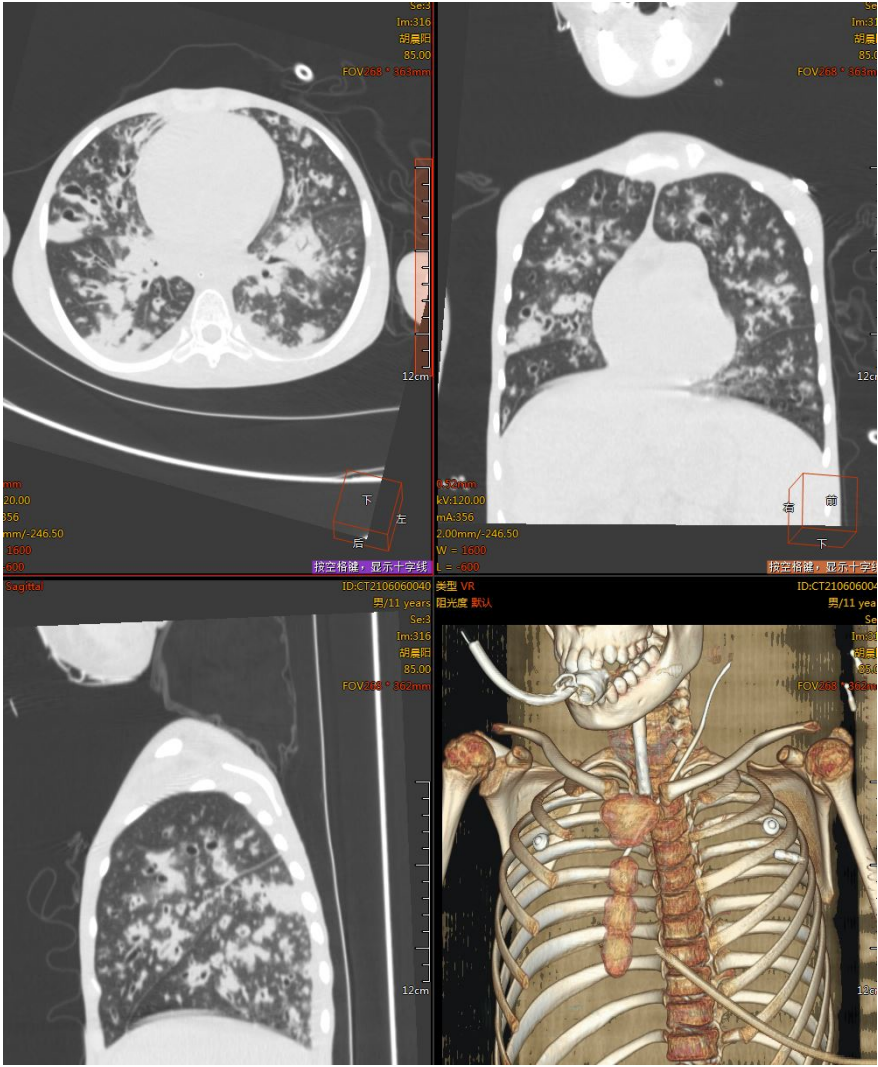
Chest CT images of a Chinese boy with CF at the first time presented to Henan children's hospital (A) and the last hospitalization before his death (B), showing the deterioration of the lung structure and progressive bronchiectasis with extensive mucus plugging.
